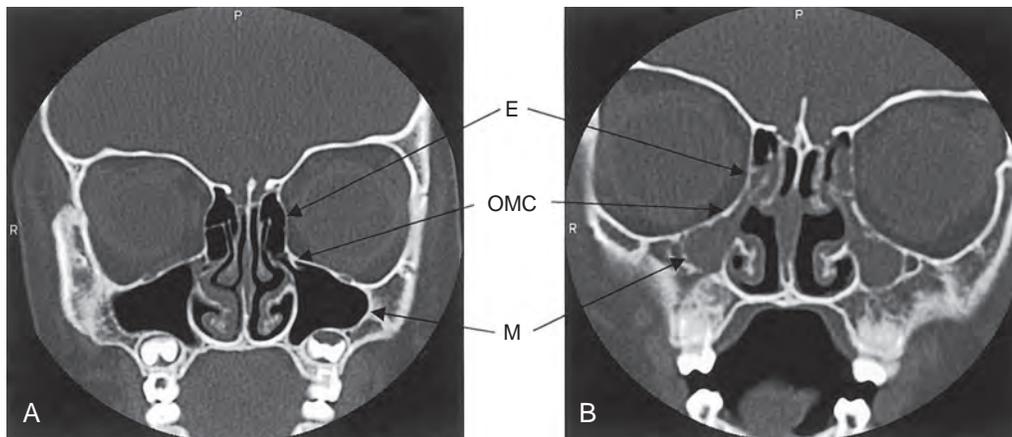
Computed tomography scans of the paranasal sinuses. Coronal views of a 4-year-old child with (A) normal maxillary and ethmoid sinuses and patent osteomeatal complex and (B) opacified maxillary and ethmoid sinuses consistent with sinusitis. E – Ethmoid sinus; M – Maxillary sinus; OMC – Osteomeatal complex.
